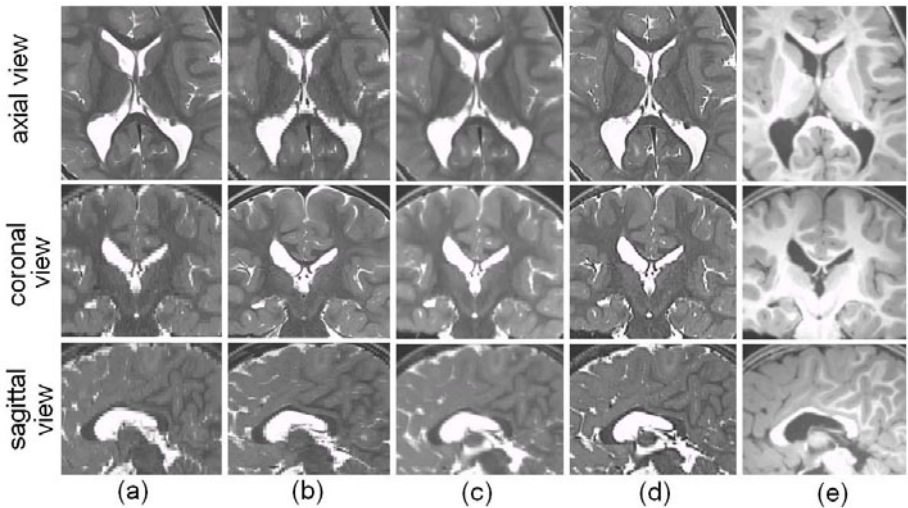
Application of the volume reconstruction algorithms to T2-weighted TSE images of a 3-year old child: Two thick-slice TSE scans were acquired and used for reconstruction in the (a) axial and (b) coronal directions; (c) and (d) are the volumes reconstructed using the SDI approach and the MAP estimation approach, respectively, and (e) is the acquired high-resolution T1W MPRAGE volume
